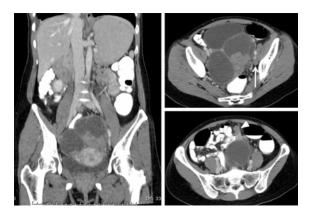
Abdominal CT scan of this patient, A) Coronal plane of whole abdomen demonstrates bilateral large ovarian thin-walled cystic lesions with enhancing solid portion. B) Axial plane of lower pelvic cavity demonstrates an enlarged left external iliac lymphadenopathy (arrow). C) Axial plane of the upper pelvic cavity demonstrates an irregular enhancing solid nodule which represents peritoneal seeding (arrow head).
